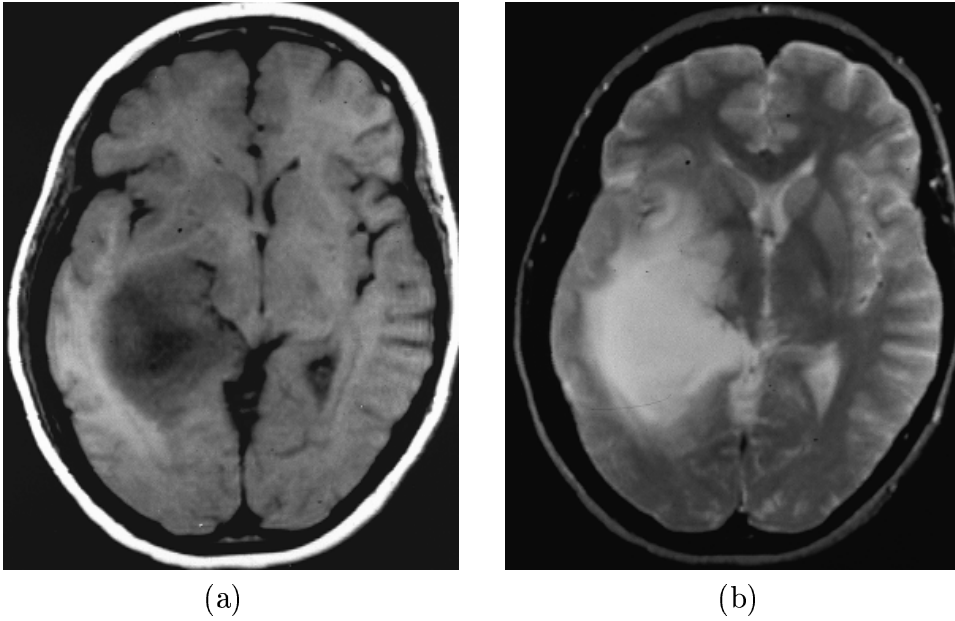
T1-weighted (a) and T2-weighted (b) MRI images of a patient with glioblastoma multiforme in the right temporal lobe.
